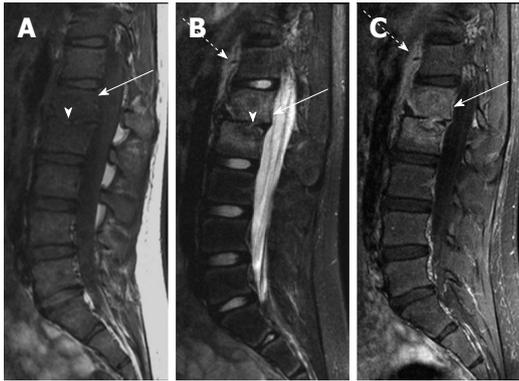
Chronic vertebral diskitis-osteomyelitis secondary to *S. typhi*. A: Sagittal T1-weighted image shows abnormally decreased T1 marrow signal in the L1 and L2 vertebral bodies (arrow) and loss of the L1-2 disk space (arrowhead); B: Sagittal T2-weighted image with fat suppression shows abnormally increased T2 signal in the L1 and L2 vertebral bodies (solid arrow) with loss of normal T2 intervertebral disk signal (arrowhead). T2 hyperintensity anterior to the spine (dashed arrow) likely represents adjacent soft tissue edema; C: Sagittal T1-weighted image after intravenous contrast shows intramedullary enhancement in the L1 and L2 vertebral bodies (solid arrow) with soft tissue enhancement anterior to the spine (dashed arrow).
